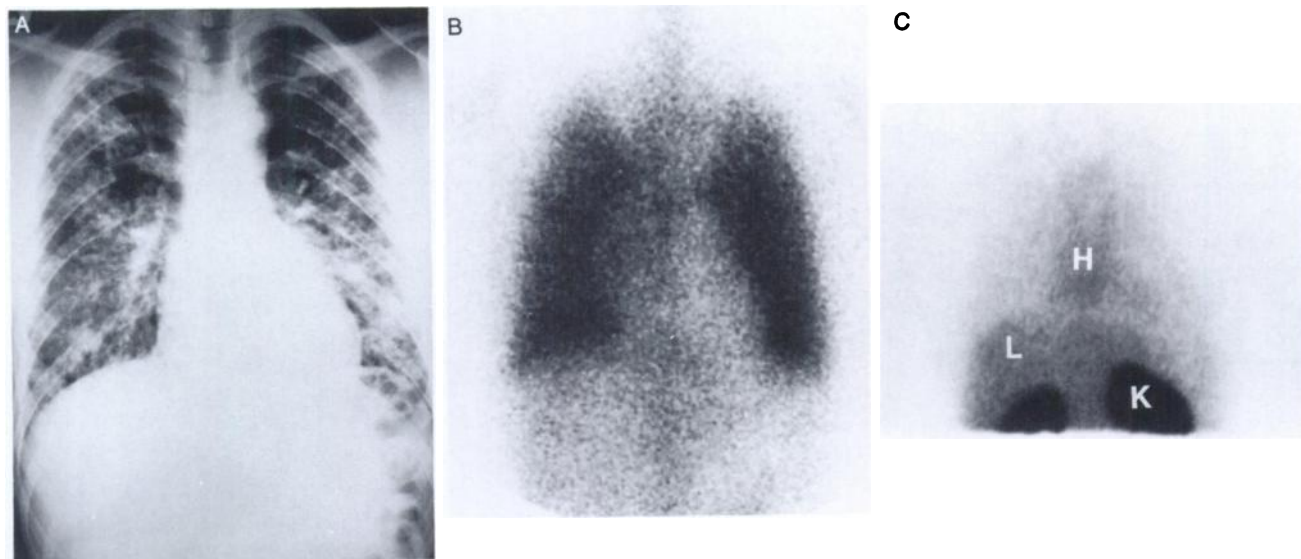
Diagnostic studies of an HIV-infected patient (#1371) presenting with suspected PCP that proved to be cytologically negative for *P. carinii*. (A) PA chest roentgenogram shows diffuse bilateral pulmonary infiltrates; (B) 48-hr ^{67}Ga scan shows diffuse bilateral pulmonary uptake; (C) 5-hr anterior chest antibody scan shows no pulmonary uptake. H = heart; L = liver; K = kidneys.
